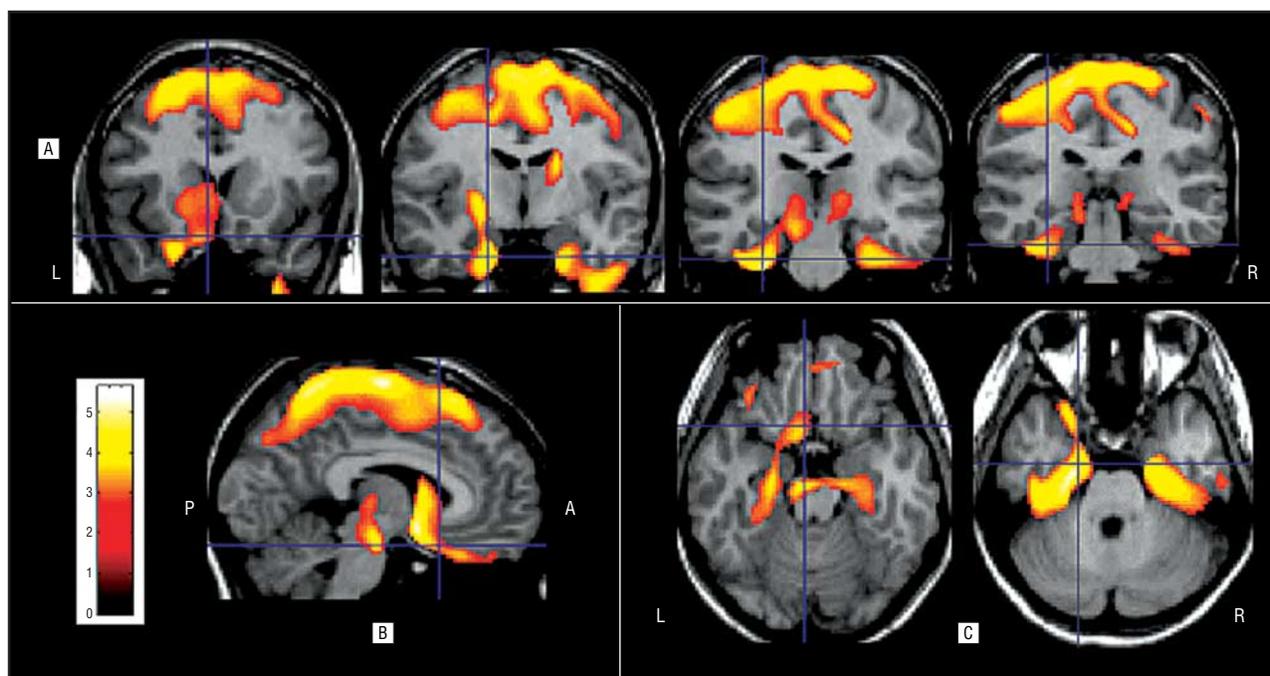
The brain regions showing decreased glucose metabolism after lamotrigine administration in patients with idiopathic generalized epilepsy. A, Cerebral metabolism decreased in bilateral thalami, the striatum, bilateral superior frontal gyri, the left middle frontal gyrus, left pericentral gyri, the right superior parietal lobule, the left entorhinal area, bilateral parahippocampal gyri, and the right inferior temporal gyrus as a T1 template overlaid magnetic resonance imaging after lamotrigine administration (at false discovery rate [FDR]-corrected $P < .05$). The order of left to right panels is arranged in the anterior to posterior direction in coronal images of the brain. B, Cerebral metabolism decreased in the left rectosubcallosal gyrus in a sagittal image (at FDR-corrected $P < .05$). C, Cerebral metabolism decreased in bilateral substantia nigra and bilateral basal temporal regions in axial images (at FDR-corrected $P < .05$). The order of left to right panels is arranged in the superior to inferior direction in axial images of the brain. The left side of the images represents the left side of the brain. A indicates anterior; L, left; P, posterior; and R, right.
